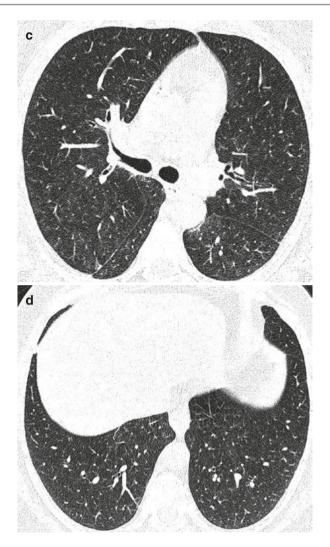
(a) HRCT of the lungs: centrilobular and paraseptal pulmonary emphysema. (b) HRCT of the lungs: centrilobular and paraseptal pulmonary emphysema, centrilobularly fine GGO. (c) HRCT of the lungs: centrilobular GGO. (d) HRCT of the lungs: costophrenic angles without significant changes
